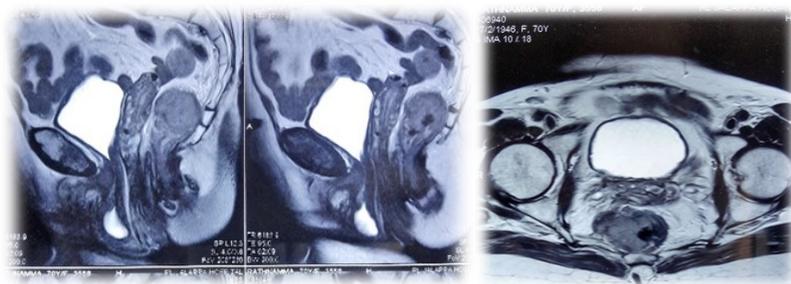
Rectal mass on MRI
